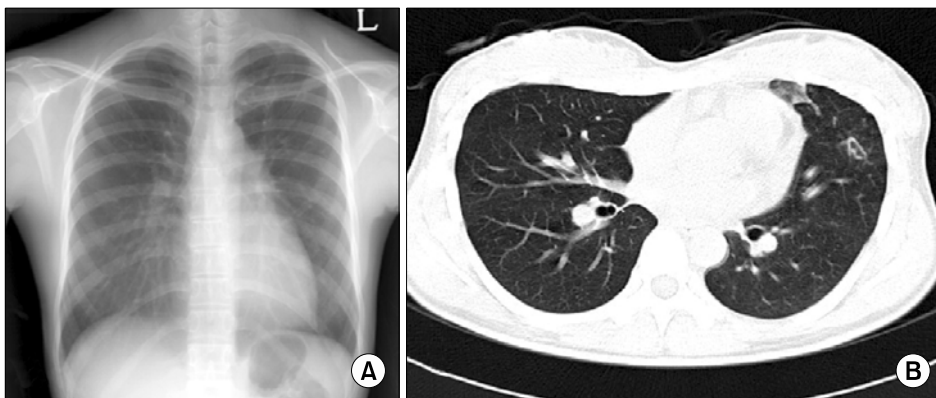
1 month after praziquantel medication for paragonimiasis. (A) Chest radiography shows improvement of nodular lesion at left upper lobe. (B) High resolution computed tomography shows improvement of cystic lesions and consolidation.
